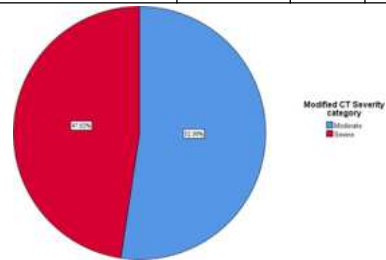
Graphical representation of the Modified CT severity Index category among the patients (n=21)
